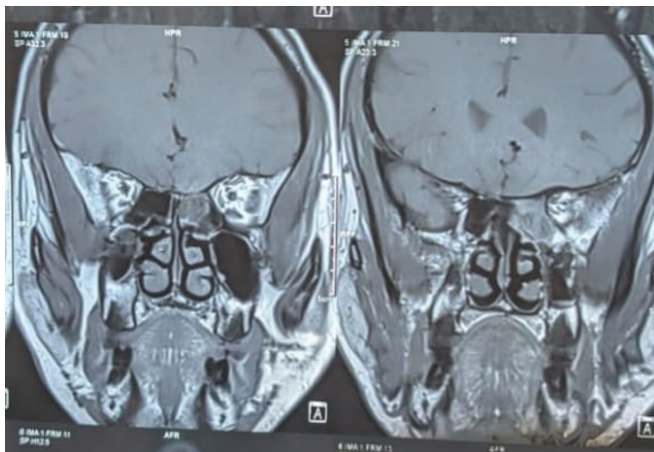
MRI showing the heterogenous opacity in the posterior ethmoid
